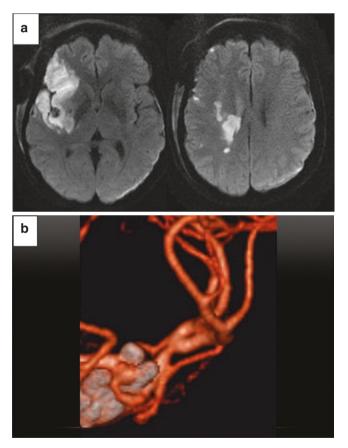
Postoperative magnetic resonance imaging (a) demonstrates brain infarcts in the frontal M2 territory and perforator region. Three-dimensional computed tomography angiography (b) shows complete occlusion of the aneurysm and a patent M2-to-M2 bypass
